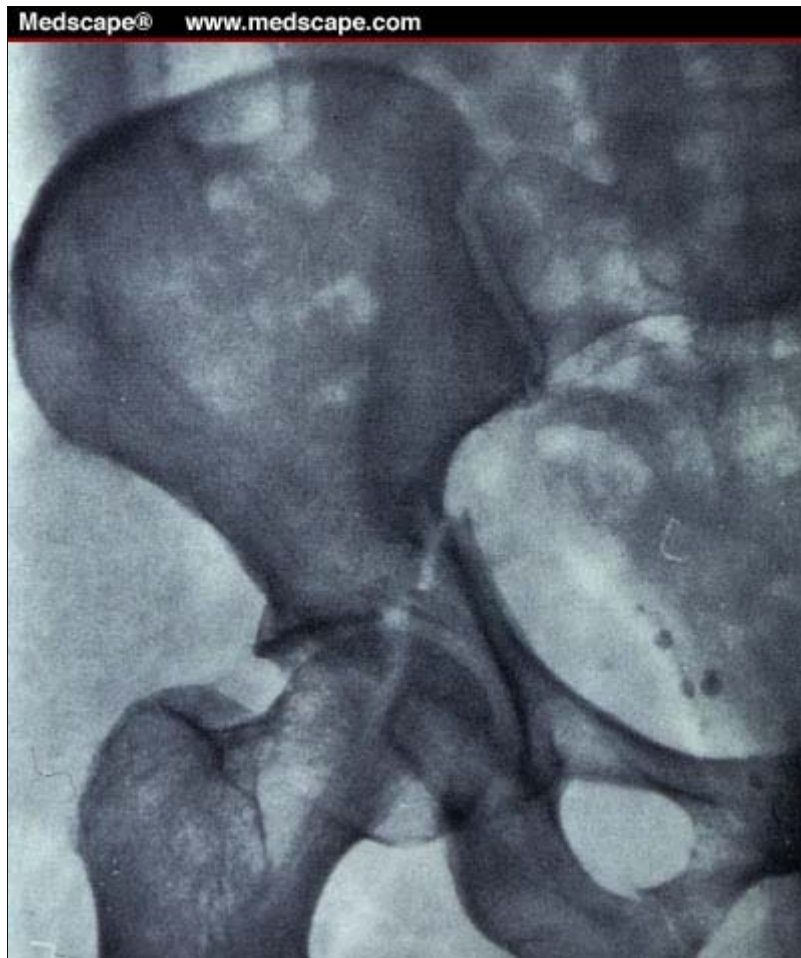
Radiograph of a T-type fracture. Note the undisplaced fracture in the ischiopubic ramus. This break in the obturator ring correlates with an additional fracture line in the quadrilateral plate.
